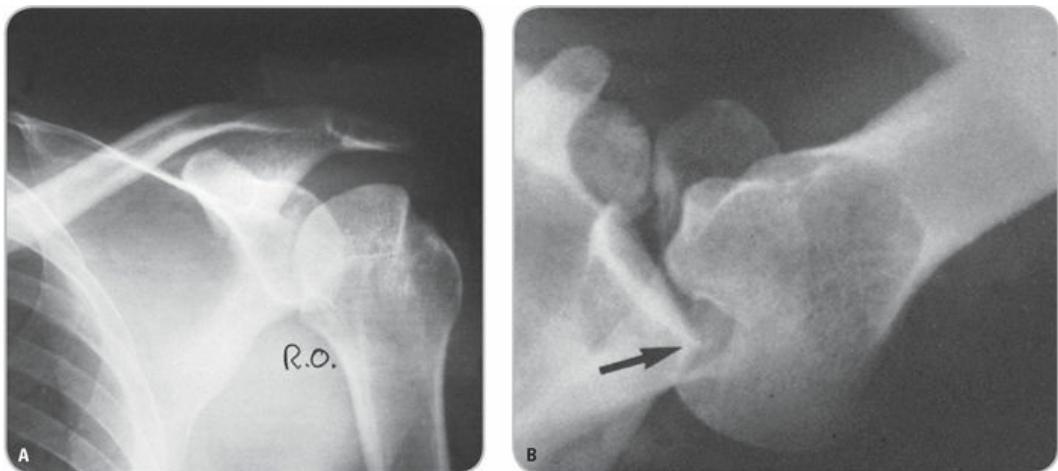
Hill-Sachs lesions. A, In this radiograph of a reduced anterior dislocation with the humeral head held in internal rotation, a Hill-Sachs compression fracture is evident. Note the posterolateral humeral head defect with a sharp, dense spine of bone running downward from the top of the humeral head toward the center of the humeral head. This line of condensation of bone is the result of an impaction fracture caused by the anterior glenoid rim. B, This radiograph demonstrates a subacromial posterior dislocation of the right shoulder with a large, antero-medial compression fracture defect of the humeral head, the so-called reverse Hill-Sachs sign (arrow).
